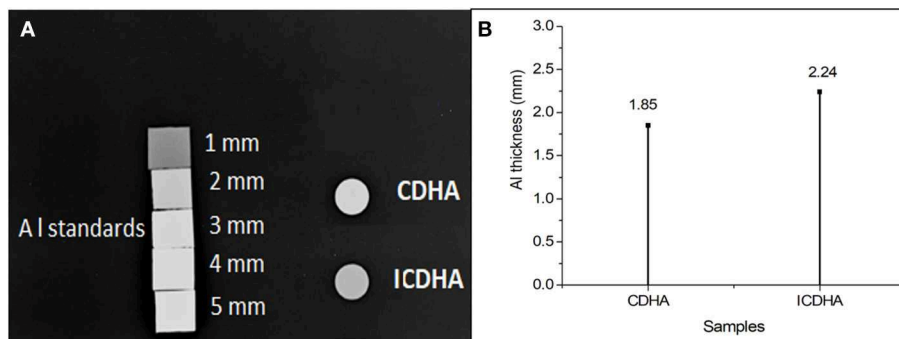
(A) X-ray and (B) grayscale value graph of CDHA and ICDHA.
